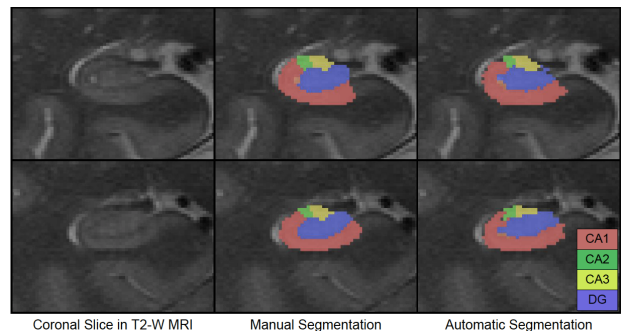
Examples of manual and fully automatic segmentation of subfields CA1-3 and DG in T2-weighted MRI data.
